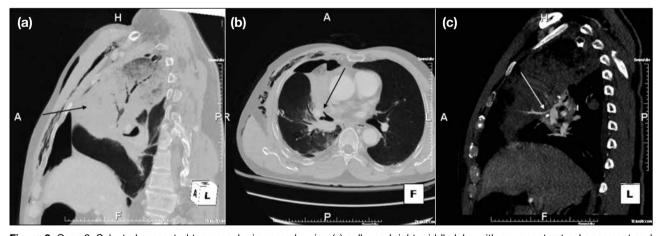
Case 2. Selected computed tomography images showing (a) collapsed right middle lobe with poor contrast enhancement and mottled appearance; (b) tapered right middle lobe bronchus; and (c) right middle lobe pulmonary artery small in calibre. Surgical emphysema is also seen in (a) and (b).
